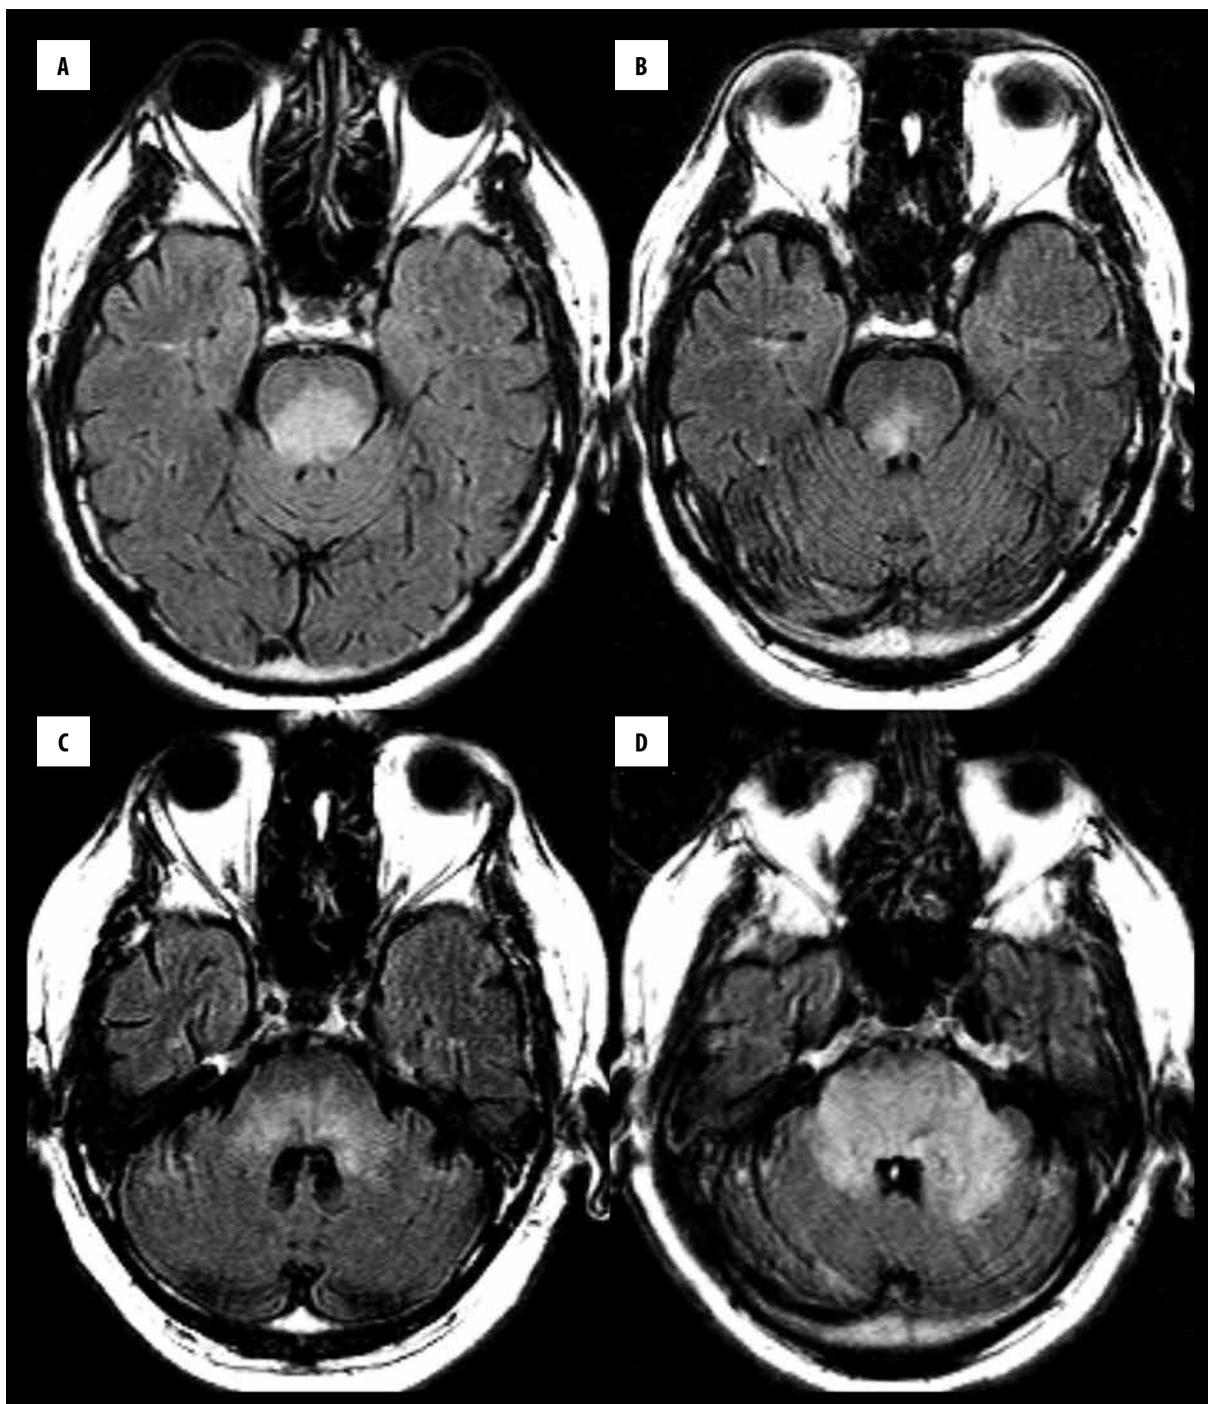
Following MRI in a 59-year-old patient with Bickerstaff encephalitis (FLAIR axial images). Admission MRI showed an irregular hyperintensity area in the dorsal pons spreading towards the medulla (A). MRI repeated after 5 months showed a significant regression of changes (B). After 1.5 year MRI showed recurrence of the previously stated lesions, with involvement of the pons, cerebral and cerebellar peduncles (C). Subsequent MRI showed a considerable increase in the extension of hyperintensity involving the brain stem and spreading towards the hemispheres of the cerebellum (D).
